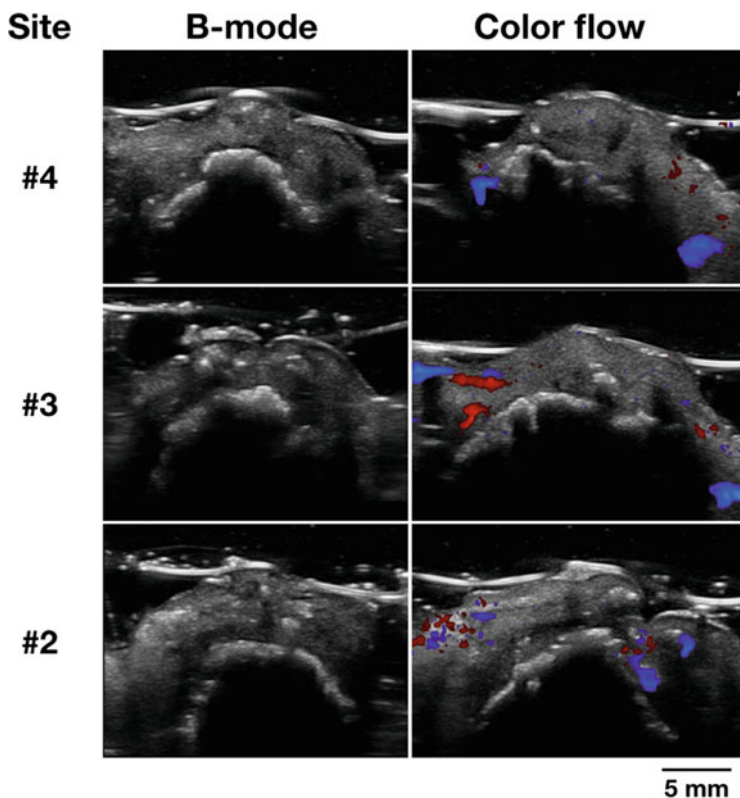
Ultrasound occlusal images of the same case at 1 week after membrane was removed. On the B-mode, there are some residual particles (hyperechoic) in soft tissue. Color flow images show much less blood flow, compared to Fig. 9.5
